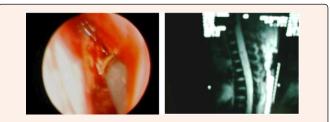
MRI Image of the Spinal Cord Implant.
